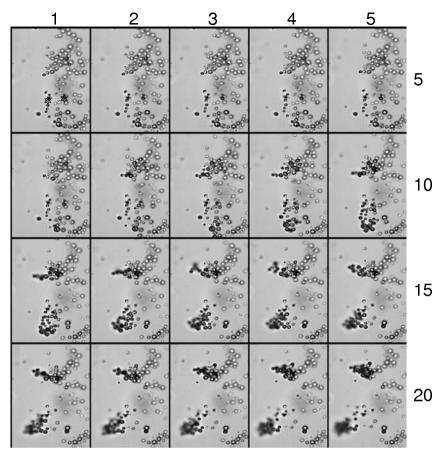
M1639 microbubbles subjected to pulsed ultrasound from a commercial echo machine, operating at a 3 MHz center frequency and a mechanical index MI=1.3. Interframe time is 100 ms. The frame corresponds to a $94.4 \times 70.8 \ \mu\text{m}^2$ area. © 2006 IEEE. Reprinted with permission from [10].
